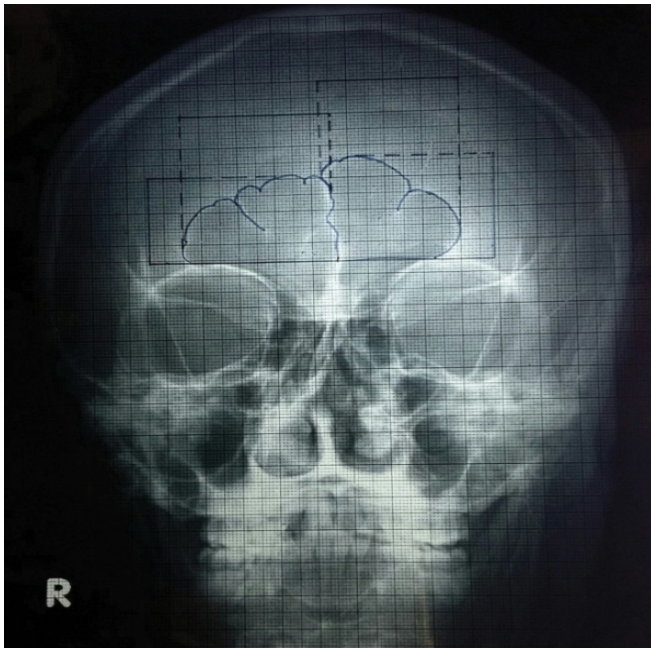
(i): procedure of tracing caldwell view radiograph.
